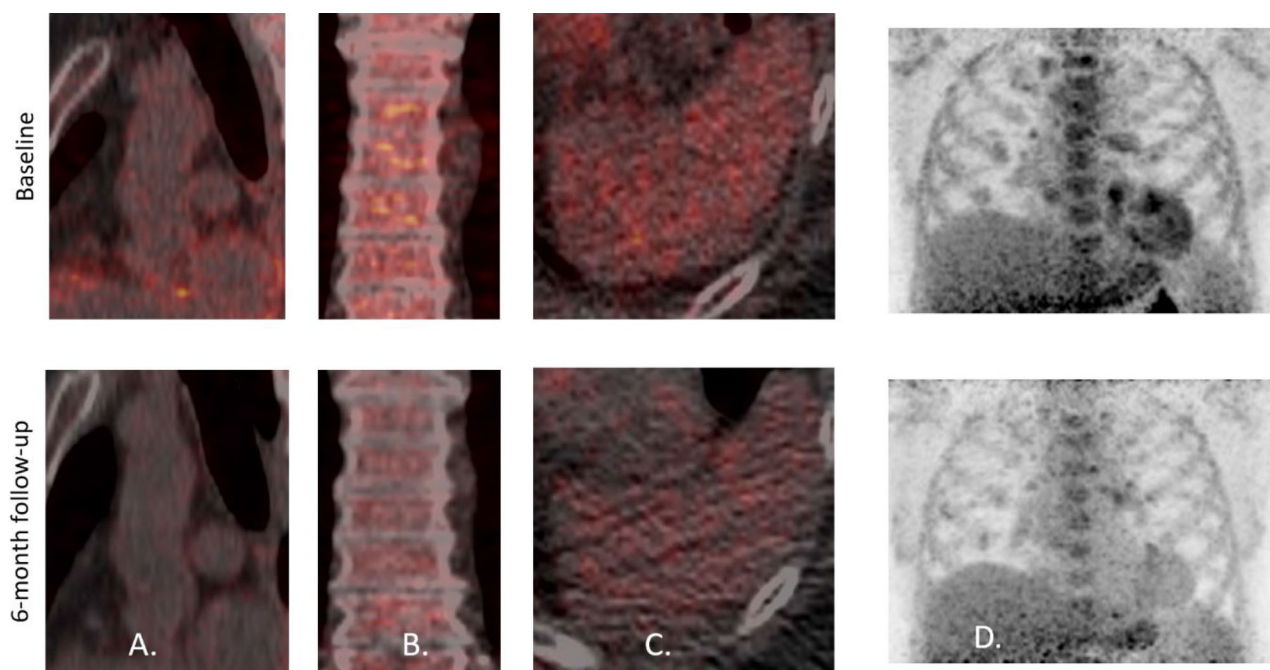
Change in FDG uptake in HIV+ patient over 6 months with treatment of rosuvastatin in (A) the ascending aorta (TBR_{max}: 2.80 at baseline and 1.39 after), (B) the bone marrow (SUV_{max}: 3.35 at baseline and 2.26 after), (C) the spleen (SUV_{max}: 3.49 at baseline and 1.70 after), and (D) anterior planar image.
